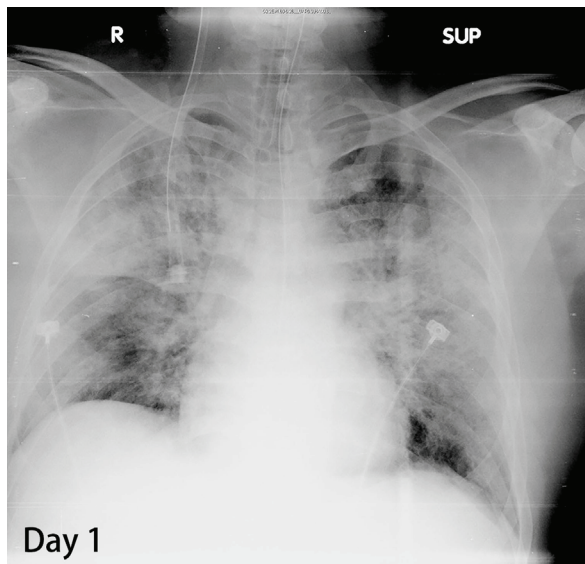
Chest radiography on day 1 after admission.
